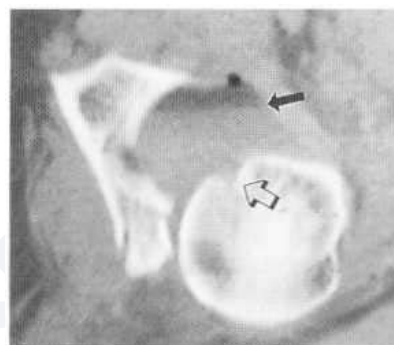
Posterior acetabular pillar fracture. CT scan demonstrates an extensive fracture of the posterior acetabular pillar, again usually associated with posterior hip dislocation. A fat-fluid level is seen in the joint (arrow), with a small collection of air anteriorly, probably a 'vacuum' phenomenon. The cortical femoral head defect is again seen (open arrow).
